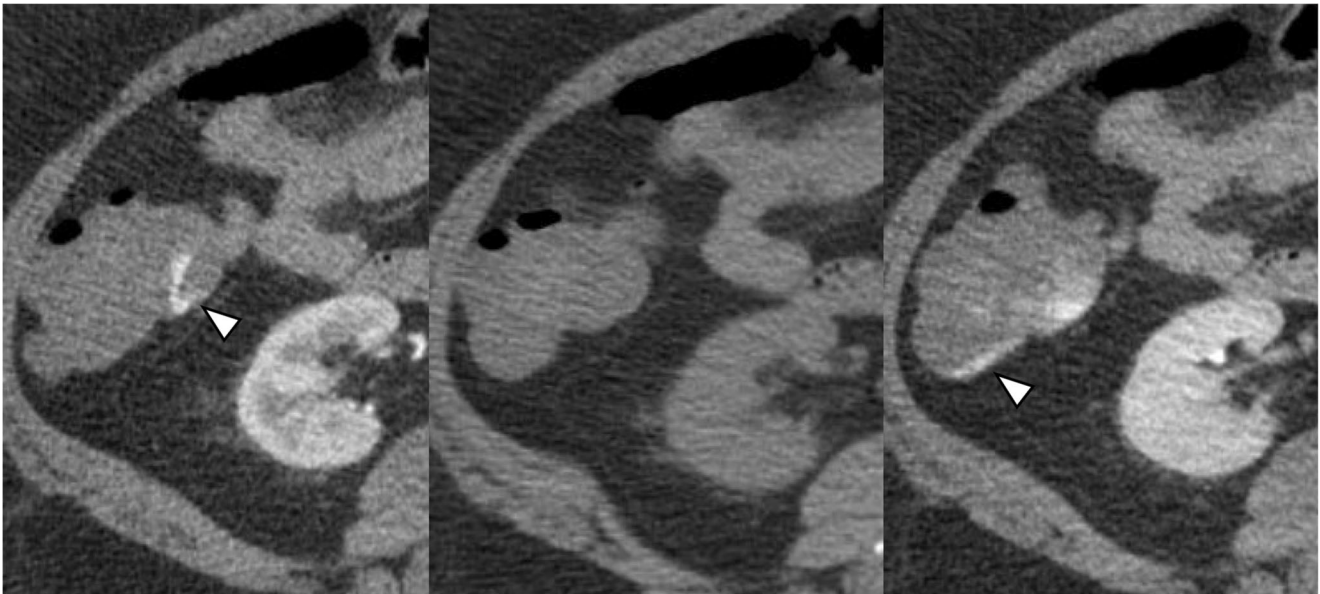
Axial triphasic protocol CTA demonstrating diverticular bleeding subsequently confirmed on colonoscopy and treated with epinephrine/clipping. Active extravasation on arterial phase (left) without non-contrast correlate (middle), which evolves on delayed images (right).
